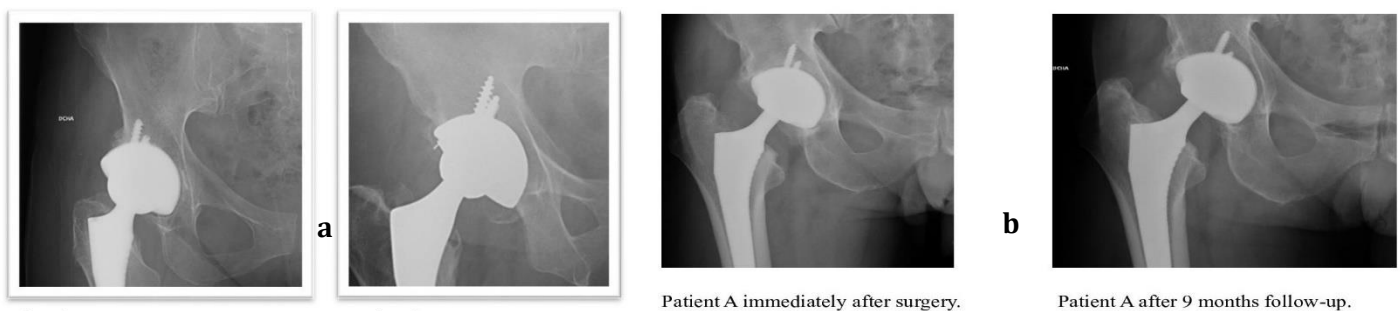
(a-b). (a) Hip anteroposterior (AP) x-rays showing lack of contact between cup and bone in zone 2 immediately after surgery. (b) Hip AP x-rays showing progressive filling of the gap between the implant and the bone during patient follow-up
